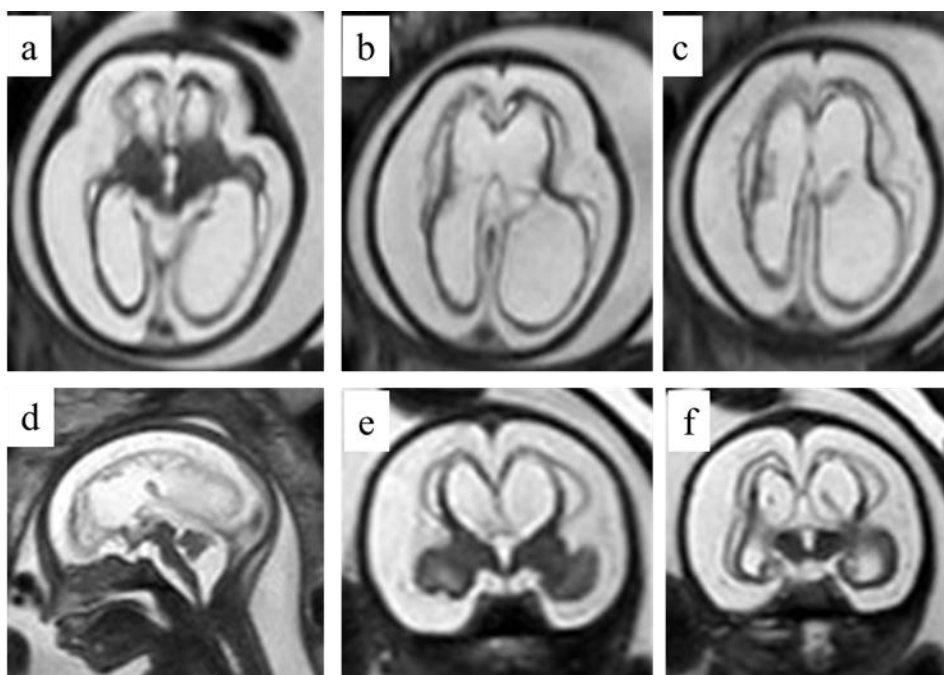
A fetus with established encephalomalacia of the cerebral hemispheres. Axial (5a-5c) sagittal (5d) and coronal (5e and 5f) T2-weighted images performed at 29gw show micro-encephaly, severe ventriculomegaly and extensive destruction of the cerebral hemispheres. This occurred in a fetus with Rhesus isoimmunisation (courtesy of Mr Umber Agarwal, Liverpool Women's NHS Foundation Trust).
